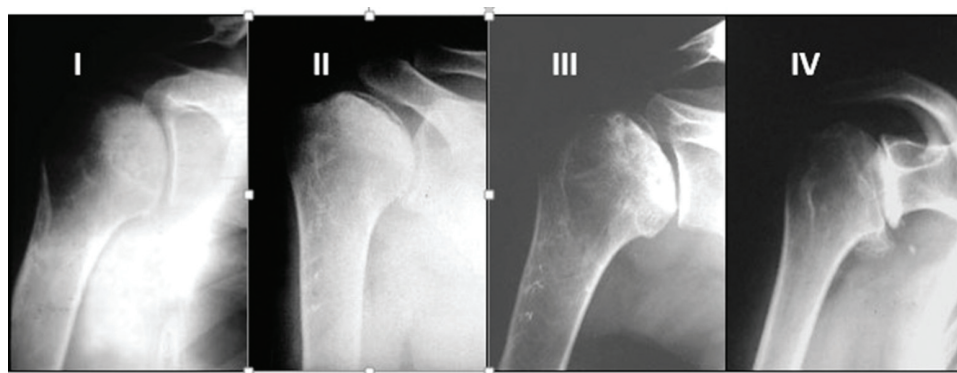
Radiographic aspect of the different stages of humeral head osteonecrosis, according to the Neer classification.⁶
